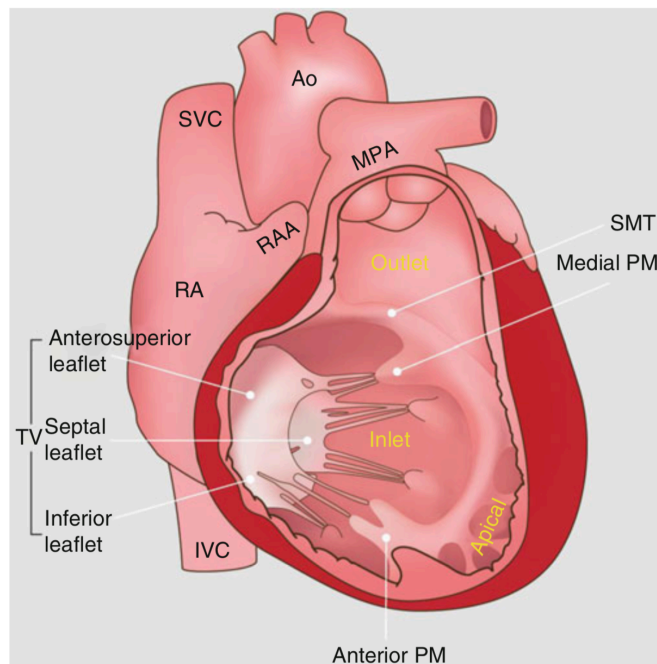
Anatomy of the right and left heart, showing the exact location of the TV, the chordae tendinae and papillary muscles. The image is from Mazur et al.'s book "CT Atlas of Adult Congenital Heart Disease"³⁶. Ao: aorta, IVC: inferior vena cava, MPA: main pulmonary artery, PM: papillary muscle, PV: pulmonary valve, RA: right atrium, RAA: right atrial appendage, SMT: septomarginal trabeculations, SVC: superior vena cava, TV: tricuspid valve.
